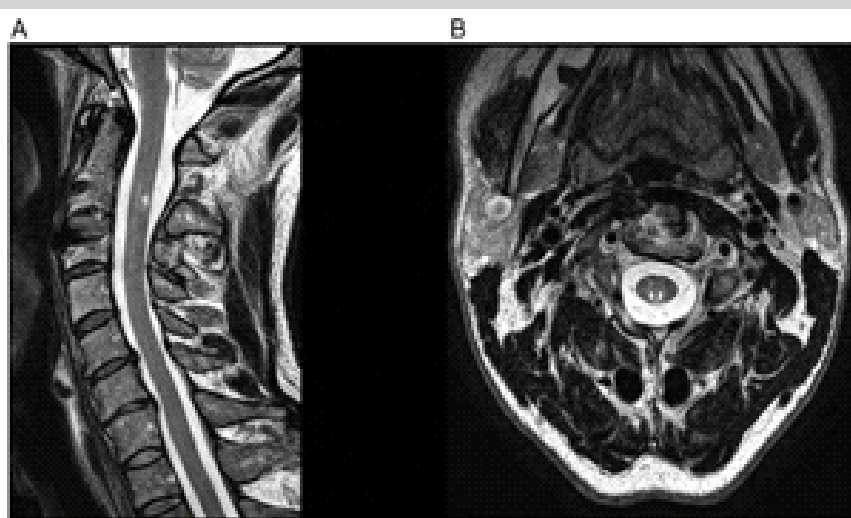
Follow-up cervical spine magnetic resonance imaging obtained at 1 year. Sagittal (a) and axial C3-level (b) images clearly demonstrate a spinal cord injury confined to the posterior columns, anatomically confirming posterior cord syndrome.
